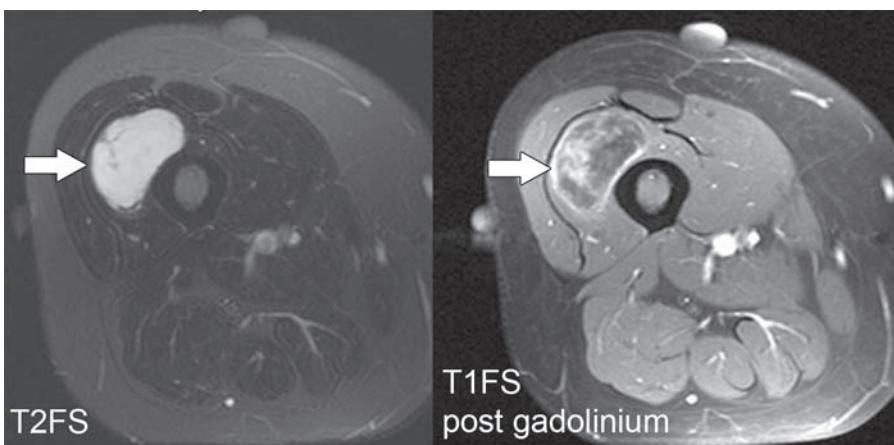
Myxoma. Left: Axial T2-weighted fat-saturated MR image shows a high-signal-intensity lesion (arrow) in the right thigh. Right: Axial gadolinium-enhanced T1-weighted fat-saturated MR image shows diffuse enhancement of the lesion (arrow); the enhancement is more prominent centrally. These findings are consistent with a solid lesion rather than a cyst.
